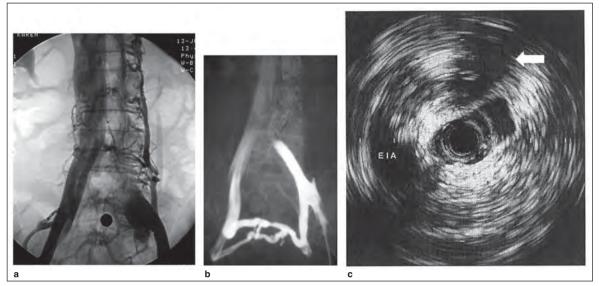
Venous obstruction due to extrinsic compression of the left common iliac vein. (a) Left iliac venogram with compression of left common iliac vein caused by overlying right common iliac artery as it crosses anterior to the vein. Posteriorly, the spine prevents displacement of the vein. This is typical of the May-Thurner syndrome with left common iliac vein obstruction. The narrowing is seen as a diagonal effacement of the contrast column coursing across the vein from upper left to lower right, corresponding to an extrinsic compression from the right common iliac artery. (b) Similar venographic appearance of the left common iliac vein in an older individual with asymmetric left leg swelling. Note the calcified aorta and right iliac artery that allow appreciation of the relationship between the crossing artery and the obstructed left common iliac vein. Also evident are numerous transpelvic venous collaterals that provide flow around the obstruction. (c) Intravascular ultrasound image with catheter located in the left iliac vein. The vein is markedly narrowed by the overlying iliac artery that is located anteriorly at 12 o'clock (arrow).
